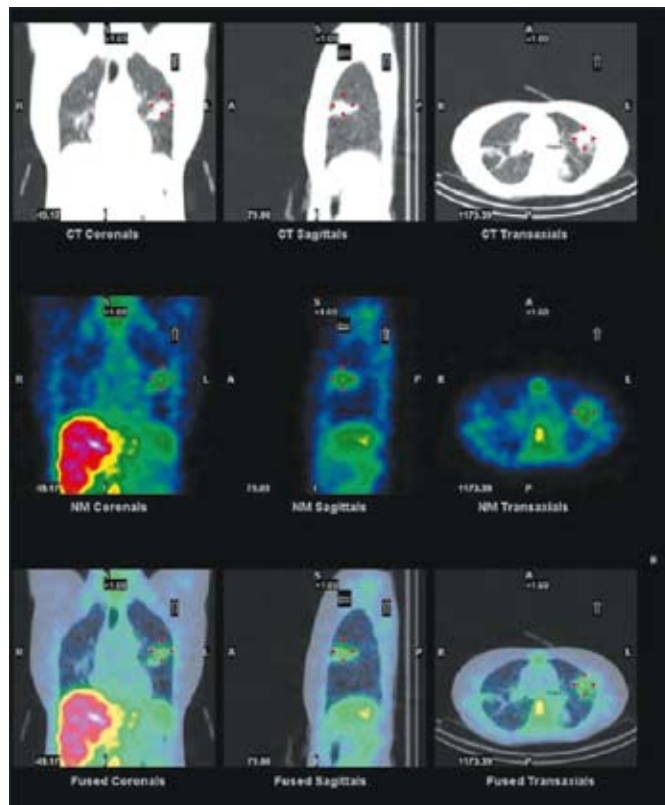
SPET/CT image of the patient with CT images (upper row) demonstrating consolidation in the middle lobe of both lungs. Gallium-67 citrate images (middle row) show uptake only in the left lung. No radiotracer uptake is noticed in the right lung consolidation. The bottom row shows fused SPET/CT images. The region corresponding to radiotracer uptake seen on CT suggests active tumor on the left and fibrosis on the right side.
